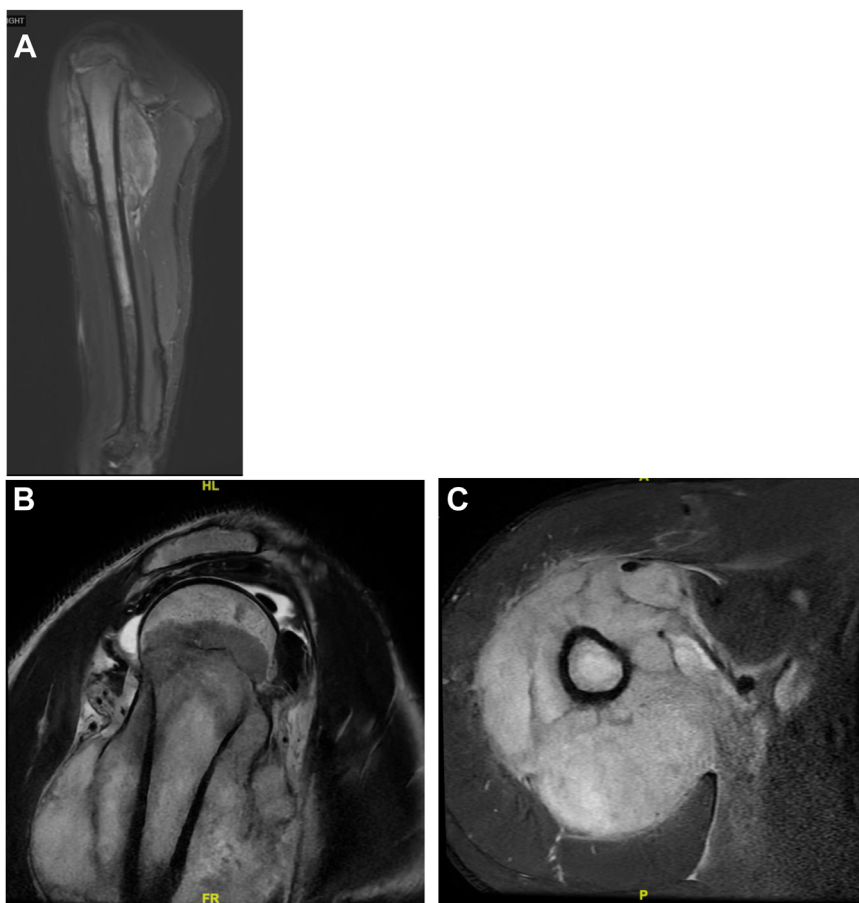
MRI of the right Humerus and Shoulder. (A) Coronal T2 weighted MRI of the R humerus demonstrating extensive soft tissue involvement. (B) Sagittal T2 weighted MRI of the R proximal humerus again demonstrating extensive soft tissue involvement. (C) Axial T2 weighted MRI of the R proximal humeral shaft demonstrating soft involvement around the shaft of the humerus. MRI, magnetic resonance imaging.
